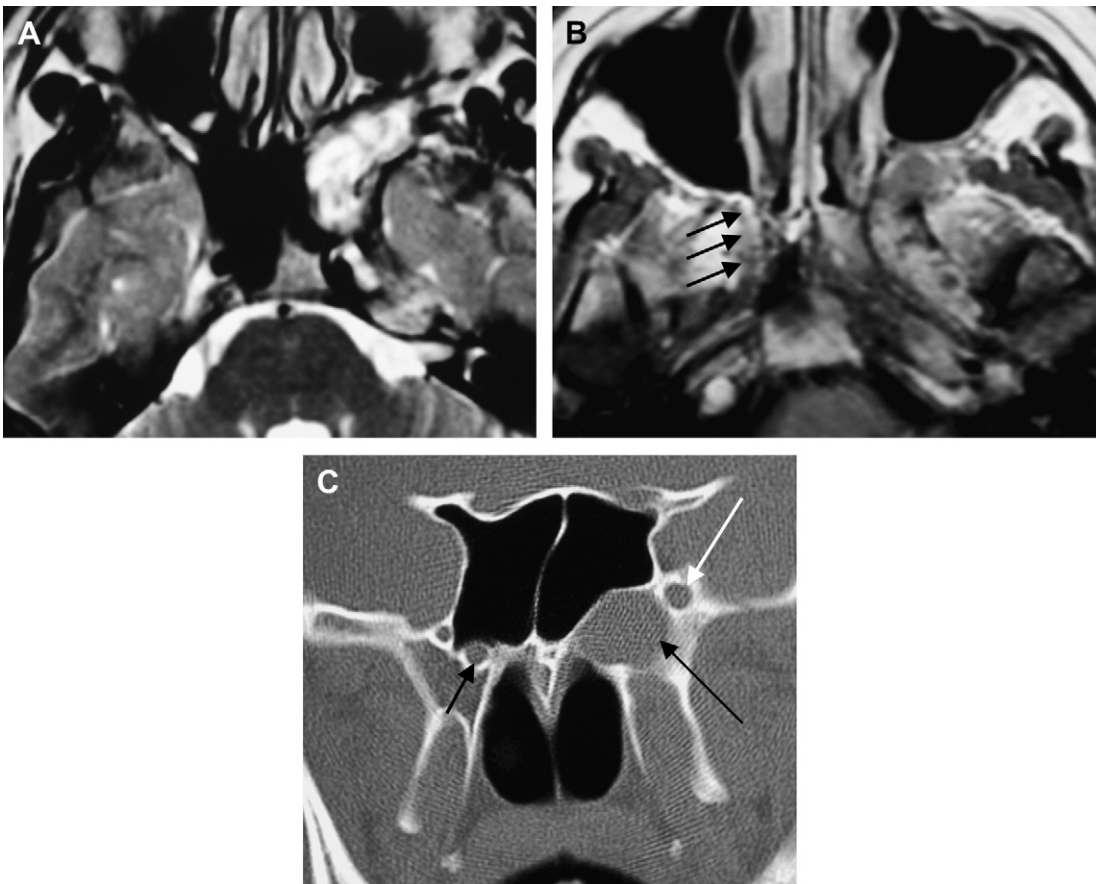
Axial T2-weighted (A) and gadolinium-enhanced T1-weighted (B) images show a sausage-shaped lesion extending from the foramen lacerum posteriorly into the high pterygopalatine fossa anteriorly, following the course of the vidian nerve. (C) Coronal CT image in the bone algorithm shows the smooth enlargement of the vidian canal (*long black arrow*) and superior displacement of the foramen rotundum (*white arrow*). Note the vidian nerve on contralateral side (*short black arrows on B and C*).
